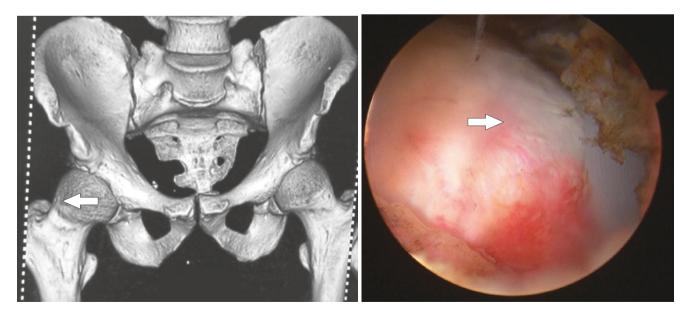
Preoperative 3D CT and in-operative arthroscopic image showed typical "Cam" deformity at right femoral head and neck (as the arrow shows)
